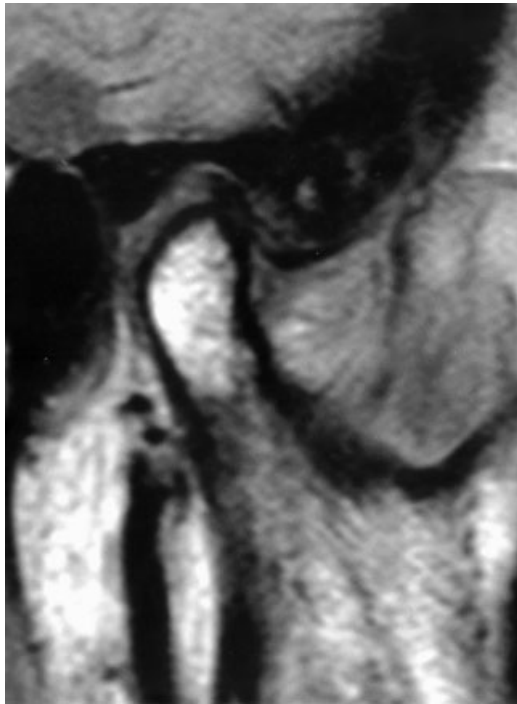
Sagittal MR image of the right TMJ at the initial consultation in October 2003. Although the disc appears to be slightly compressed, the position of the disc in relation to the condyle is normal.
